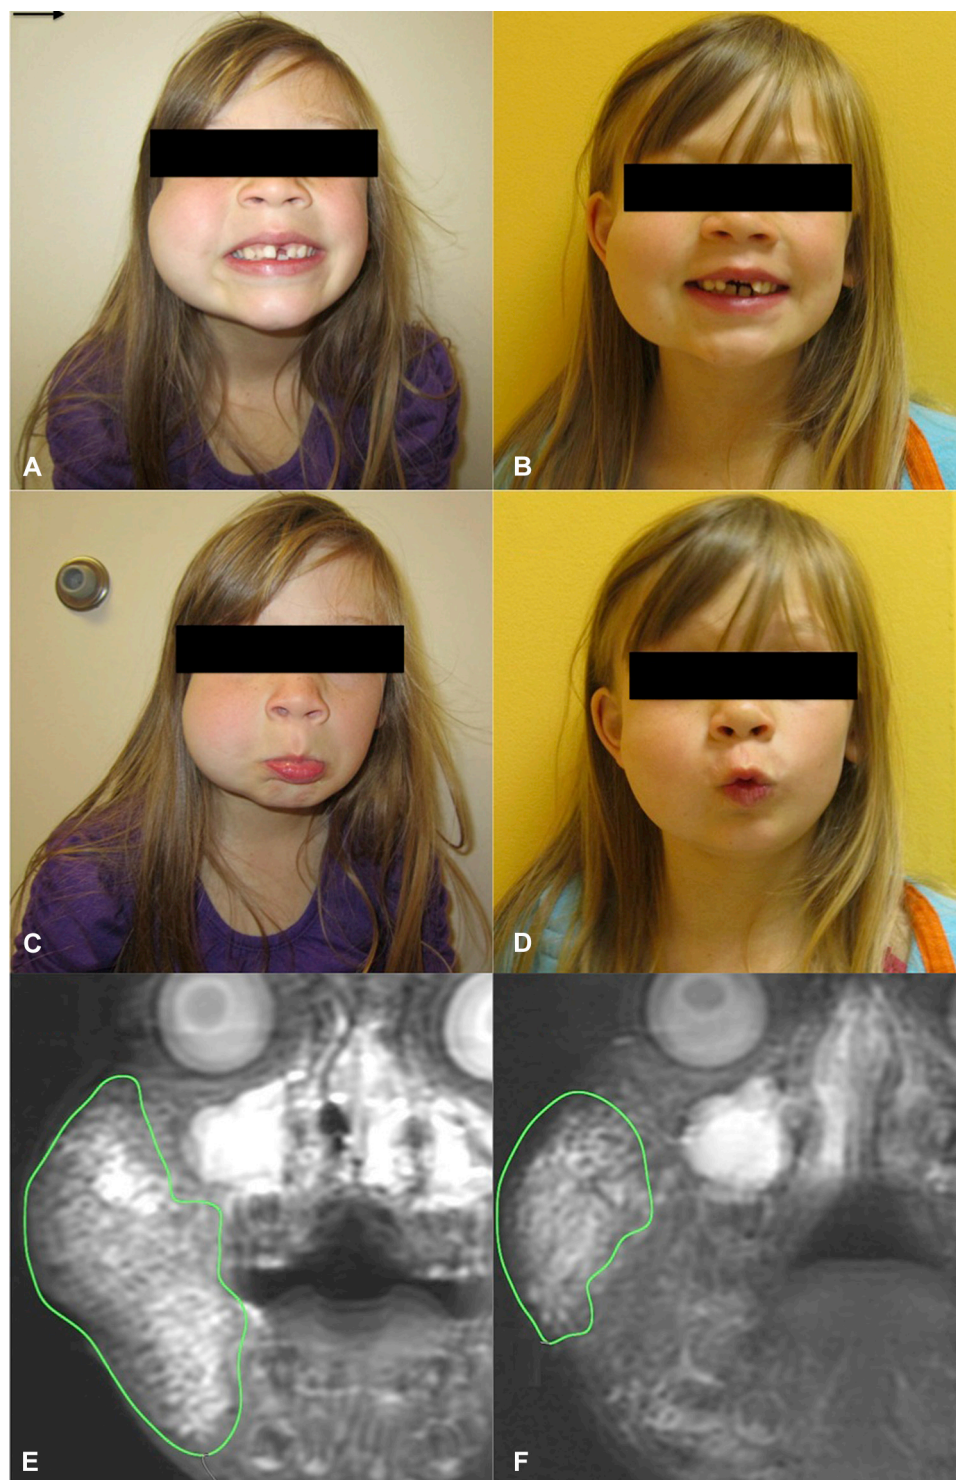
Lymphatic malformation (LM). Photographs of subject 4 at baseline (A and C) and after 20 weeks of sildenafil (B and D). Coronal T2-weighted fat-suppressed magnetic resonance images show a microcystic-predominant LM in the left superficial premandibular and premaxillary soft tissues at baseline (E) that decreased by 31.7% in volume after 20 weeks of sildenafil (F).
